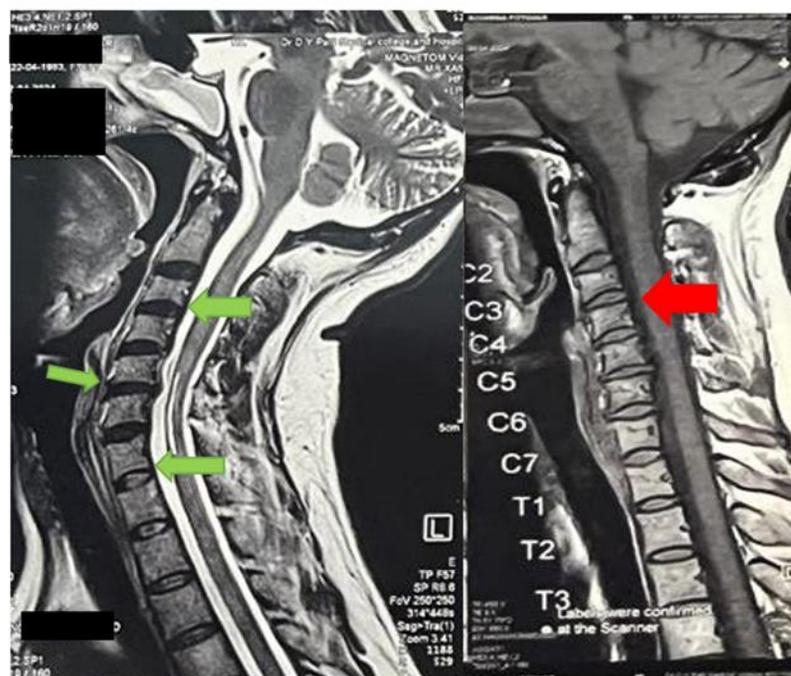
MRI of cervical spine in extension (left image), the arrow in green indicates osteophytes at multiple levels. The image on the right is an MRI in the neutral position of the cervical spine. The red arrow indicates in this image the loss of cervical lordosis. Disc bulge from C4-C7 is seen, indenting the anterior thecal sac.
